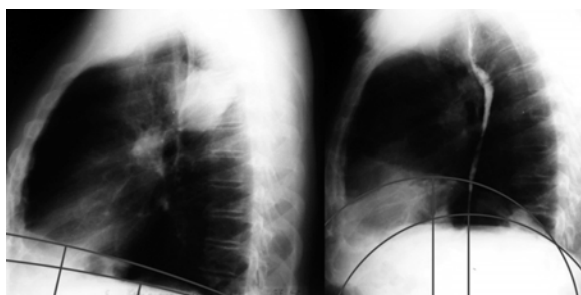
Patient K.L. Plain chest roentgenograms before and after lobectomy.
